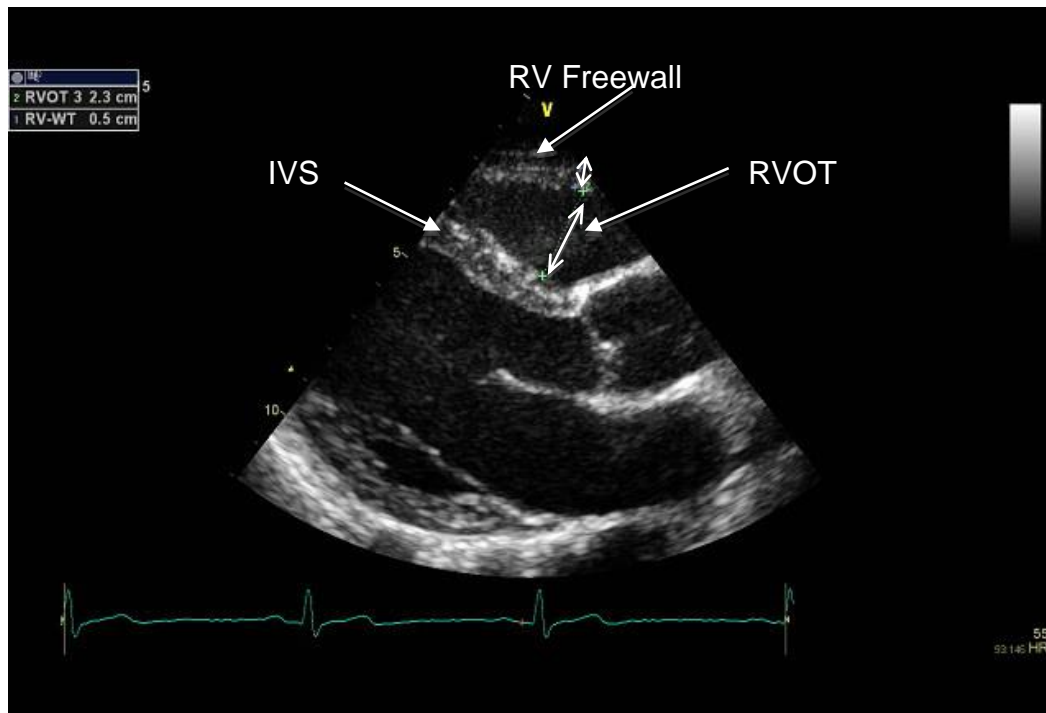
Parasternal long axis plane displaying both RVOT-3 and RV wall thickness measurements
